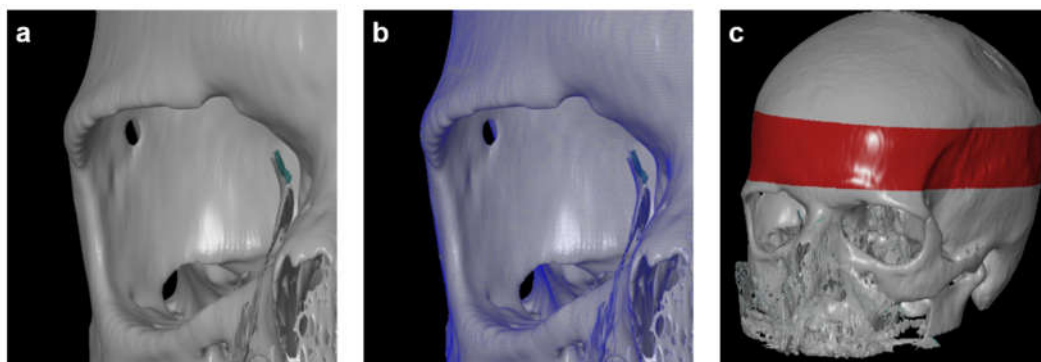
CT-OAM methodology. (a) CT data were uploaded to the image analysis software ANALYZE® 14.0. The skulls were registered with 2-D transformation using linear interpolation and reconstructed three-dimensionally. (b) Greyscale values corresponding to the respective HU were
